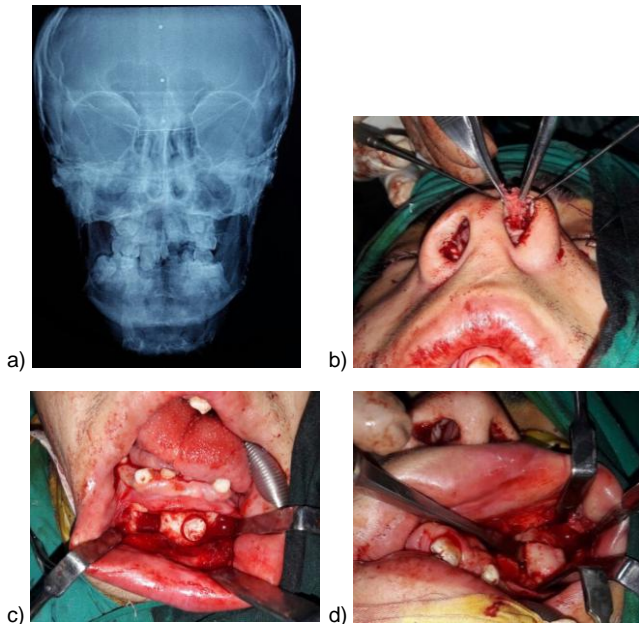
a) PA radiographic view; b) Closed surgical rhinoplasty; c) Harvesting chin bone; d) Zygomatic augmentation
